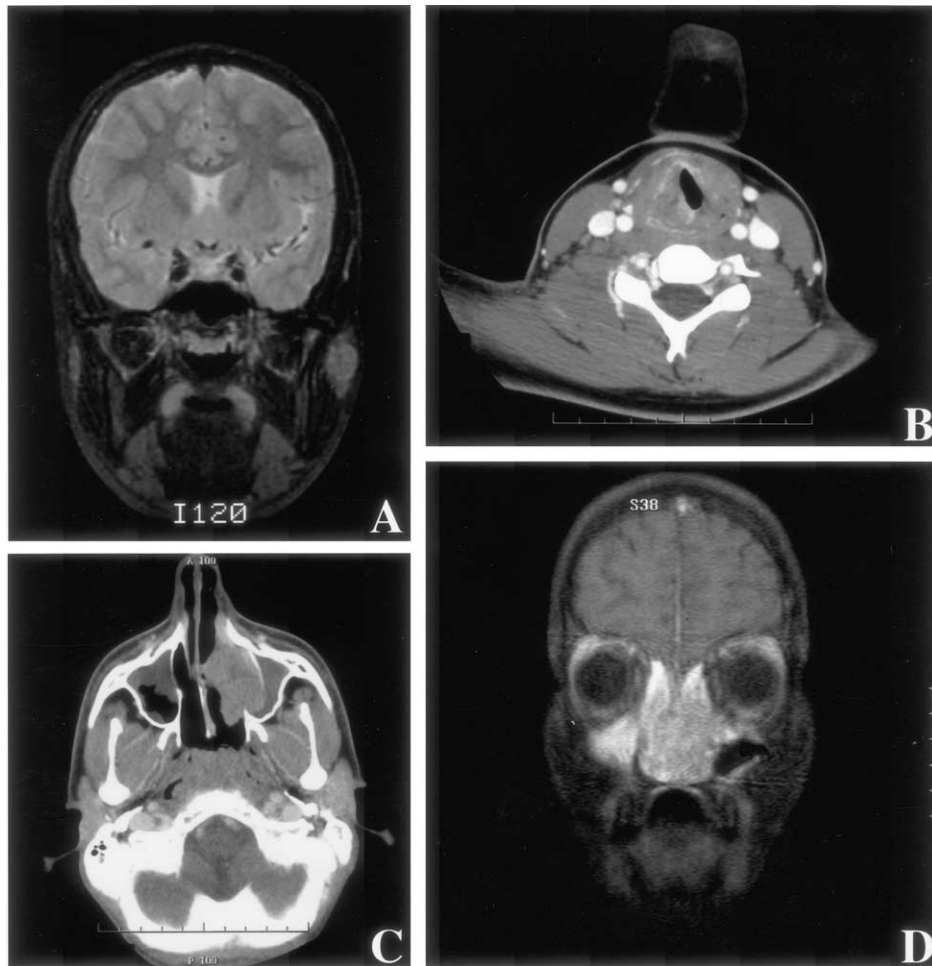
A, Coronal fast spin echo inversion recovery image demonstrates a rounded parotid tumor; B, axial contrast-enhanced CT demonstrates a poorly defined mass involving the right side and posterior aspect of the larynx; C, axial contrast-enhanced CT reveals an enhancing tumor located within the left nasal cavity with remodeling and erosion of the medial wall of the left maxillary antrum; D, coronal fat-suppressed T1 weighted MR image reveals intensely enhancing sinonasal tumor.
